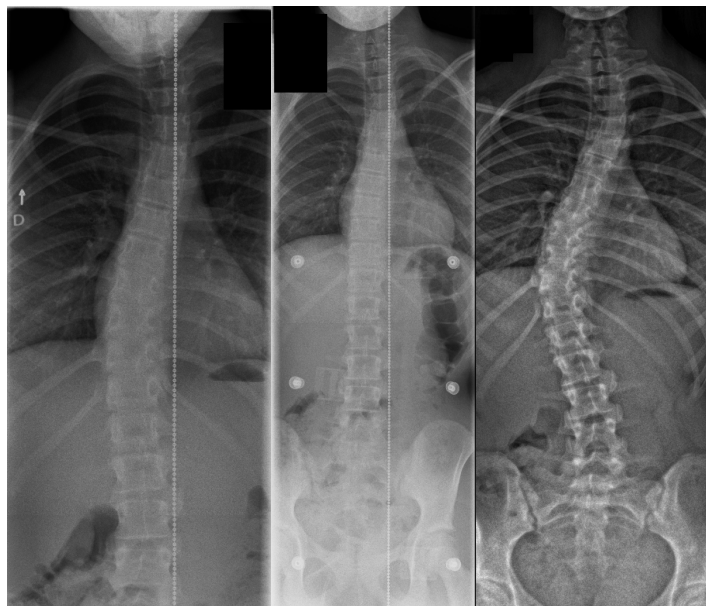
Boston brace treatment: Figs. 1-A to 1-C. 11-year-old girl with adolescent idiopathic scoliosis. Pretreatment standing radiographs (A) demonstrate a 25-degree thoracic scoliosis. Standing radiographs in brace (B) show an improved thoracic curve to 7 degrees and at 3.5-year FU (C) demonstrate a 38-degree main thoracic curve without requiring surgery.
